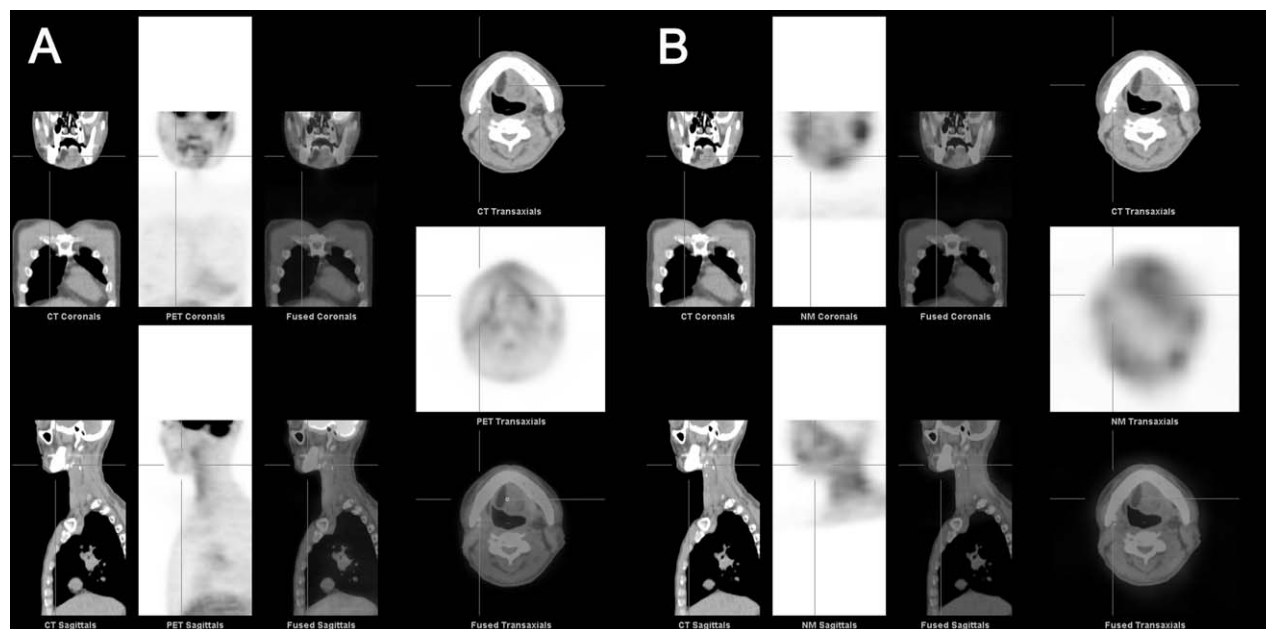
(A) FDG PET/CT for the right mandibular region. (B) Tl-201 SPECT and CT fused image for the right mandibular region. An example of negative scans in both FDG PET and Tl-201 SPECT scans in the right mandibular region.
